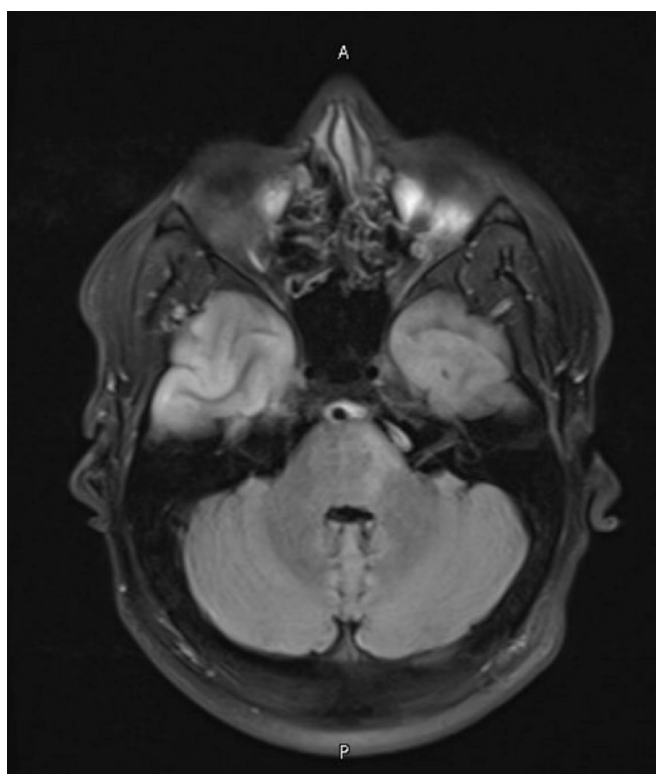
T2/FLAIR hyperintensity is observed in the left cerebellar peduncle.
